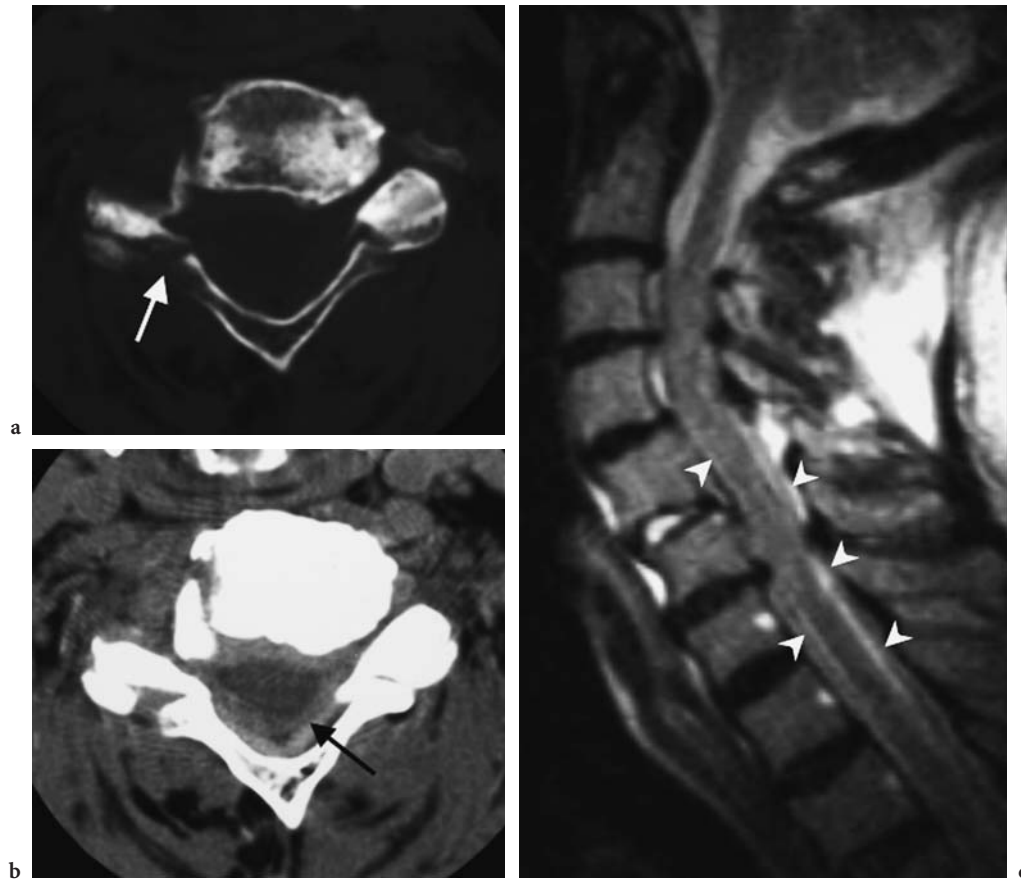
Laminar fracture. a Axial CT, bone window. The fracture line (*white arrow*) is confined to the lamina and the articular mass. b Axial CT image, soft-tissue window. Epidural hemorrhage compressing the dural sac (*black arrow*). c Sagittal T2-weighted MR image. Extensive epidural hemorrhage with secondary medullary compression (*arrowheads*)
